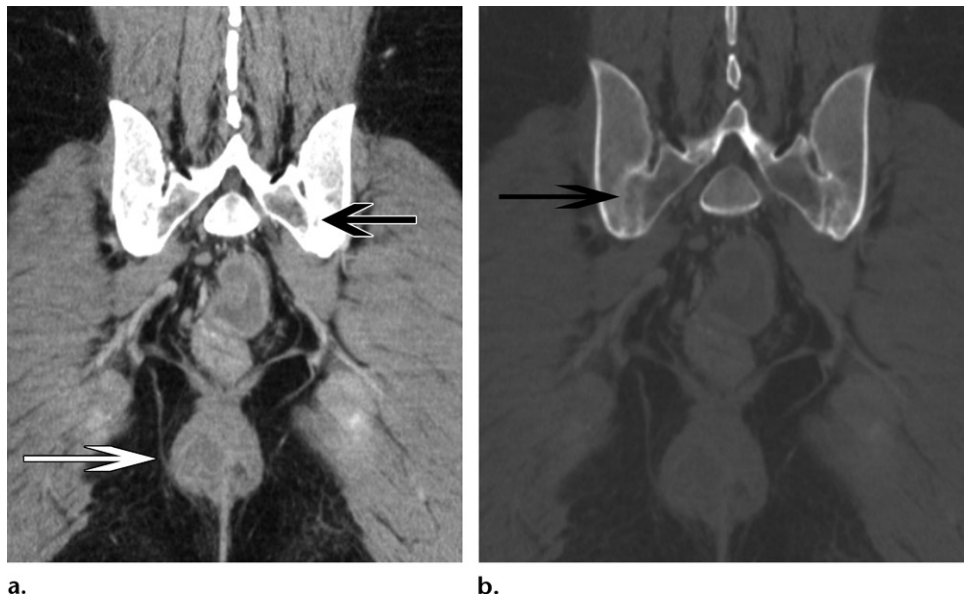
Sacroiliitis and perirectal abscess in a 29-year-old man with Crohn disease. (a) Coronal CT image shows a perirectal abscess (white arrow), with partial ankylosis of the sacroiliac joints (black arrow). (b) Coronal CT image (bone window) better depicts the blurring of the joint space with erosive change and partial ankylosis (arrow).
